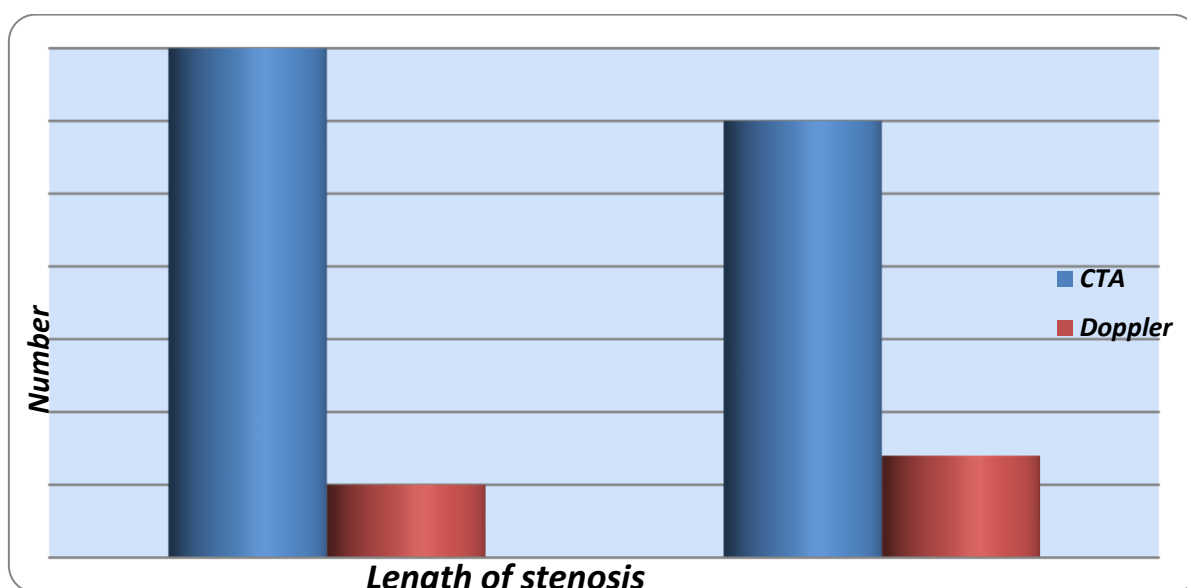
Comparison between CTA and Doppler in detecting length of stenosis.
